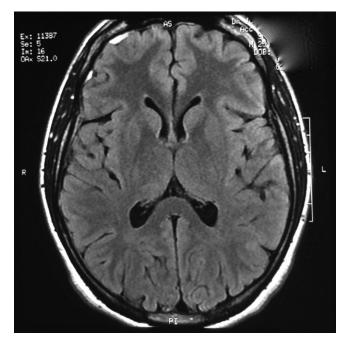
MRI showing right frontal subdural hematomas.
